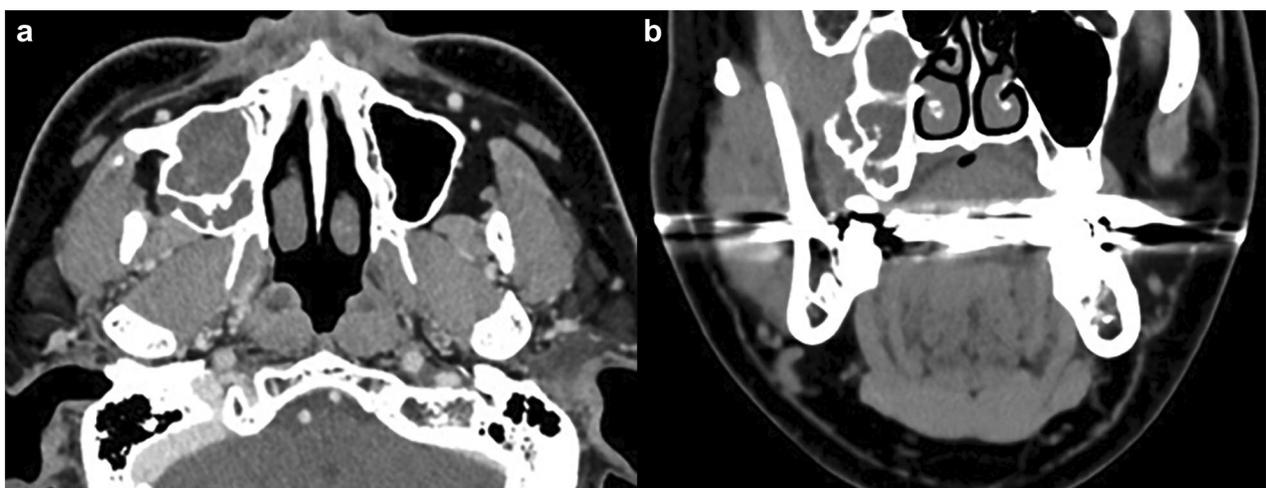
Images of case 1. Tumor fills the right maxillary sinus. a Horizontal section of computed tomography. b Coronal section of computed tomography
